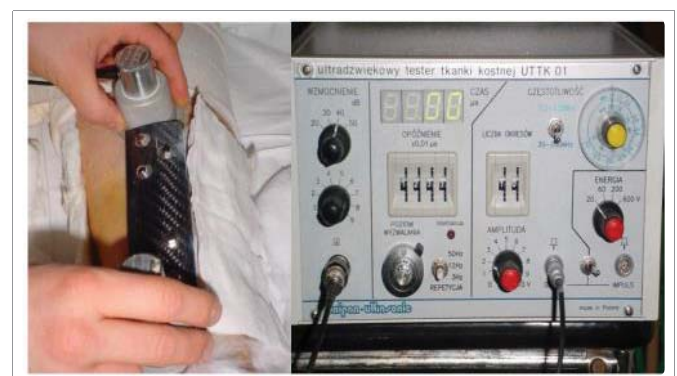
Ultrasonometer tests to assess the propagation of ultrasound wave through the fresh bone callus.
